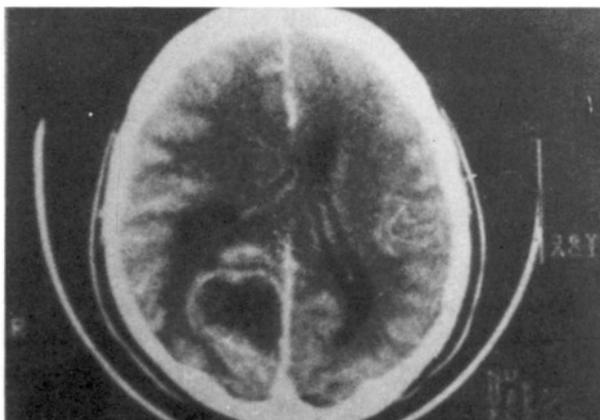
CT-scan showing decrease in the size of an anaplastic astrocytoma before (a) and six months after (b) intratumoral ADM treatment.
